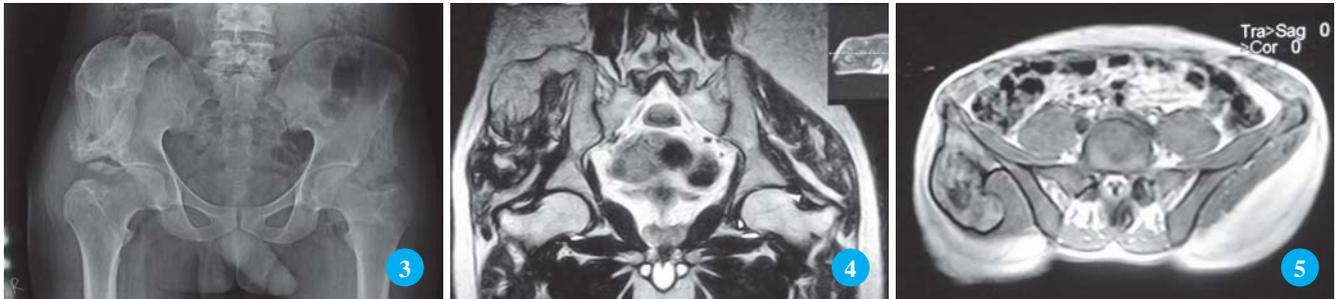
AP Pelvis Radiograph Revealed Large Irregular Ossified Mass around Right Pelvic Bone
